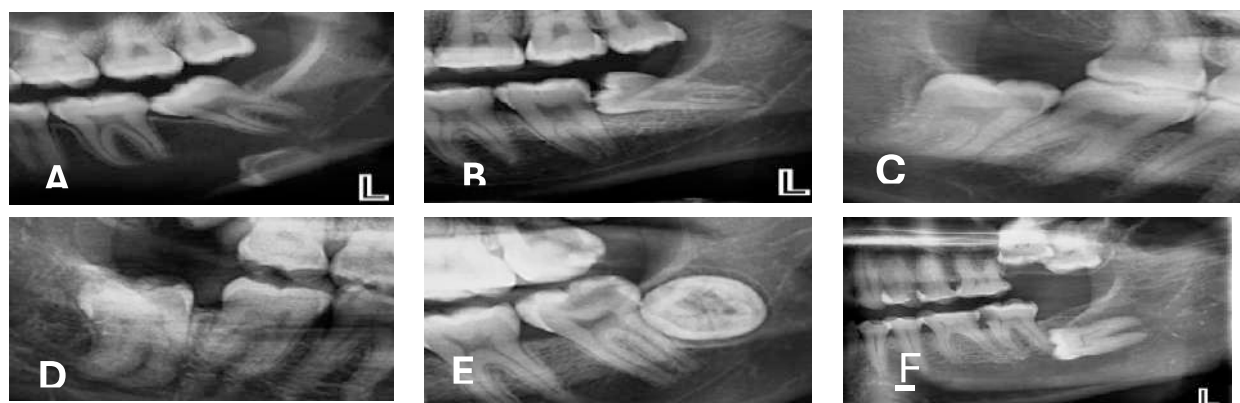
Cropped images of panoramic radiographs demonstrating Winter's Classification System of impaction of mandibular third molar showing: (a) mesioangular impaction, (b) partially bony horizontal impaction, (c) vertical impaction, (d) distoangular impaction, (e) buccolingual impaction, (f) fully intrabony horizontal impaction.²³
